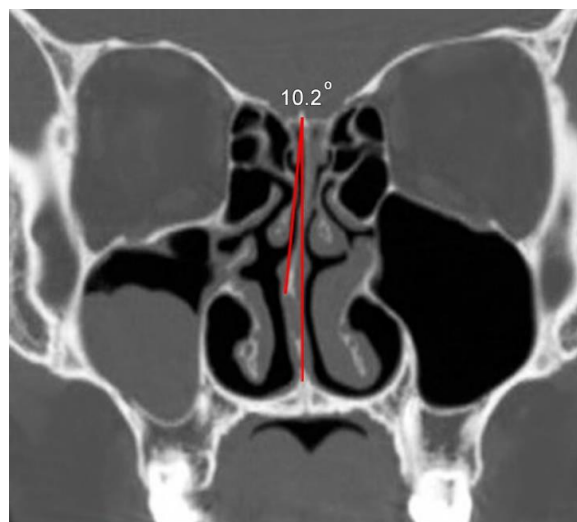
The coronal CBCT view was used for assessing nasal septum deviation.
